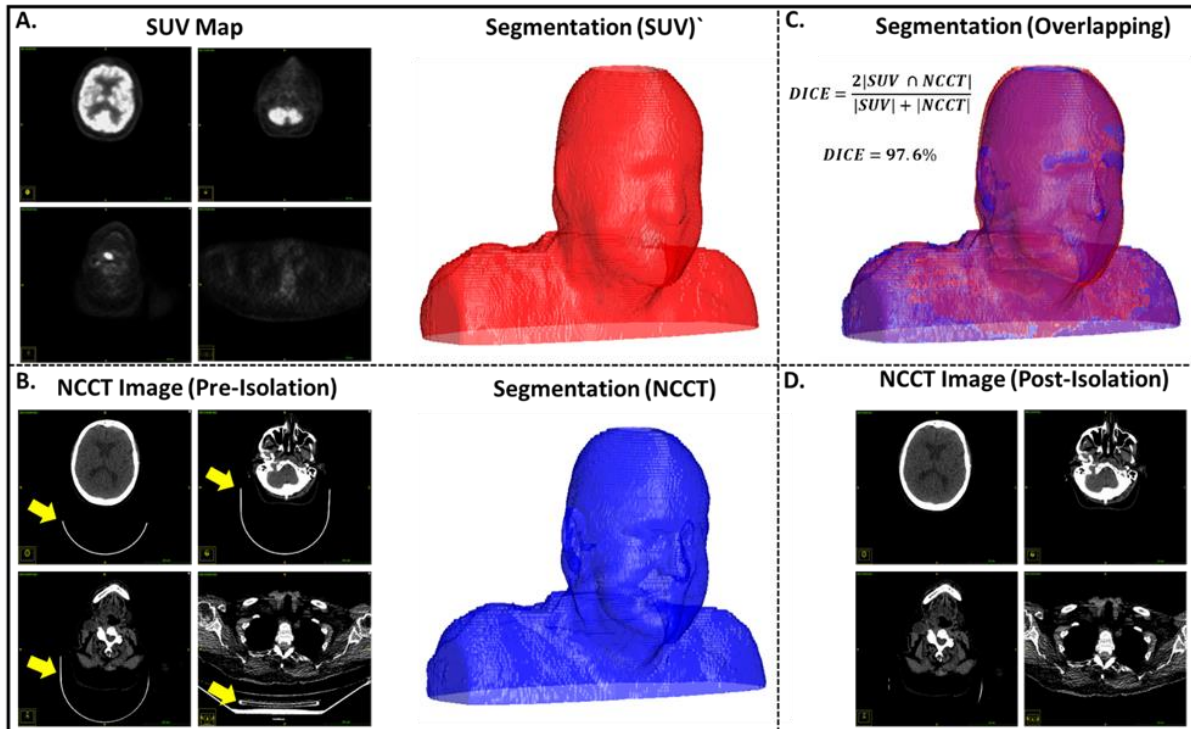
Patient Surface Contour Segmentation from Non Contrast CT and SUV Images and Image Registration. A-B. The surface contour of each patient's head was segmented from both the NCCT and SUV using threshold-based methods followed by morphological dilatation/erosion using a spherical structuring element in MATLAB. Generated segmentations were smoothed using a gaussian filter ($\sigma = 2$). C. Registration accuracy was assessed using DICE score overlap. D. Additionally, in the NCCT image, the generated segmentation was used to remove the table (yellow arrow). The post-isolated NCCT and SUV images are input for subsequent investigations.
